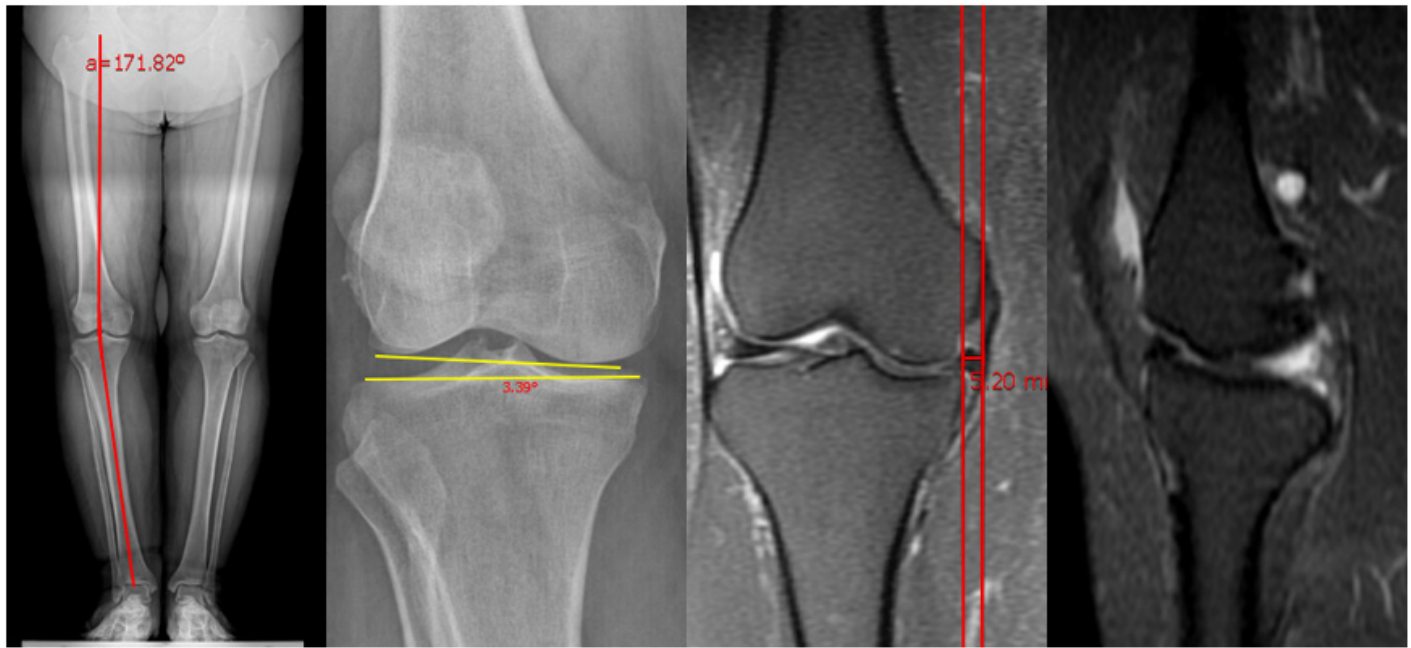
Representative case demonstrating the measurement of HKAA and JLCA on a weight-bearing full-length radiograph and medial meniscal extrusion on coronal MRI
